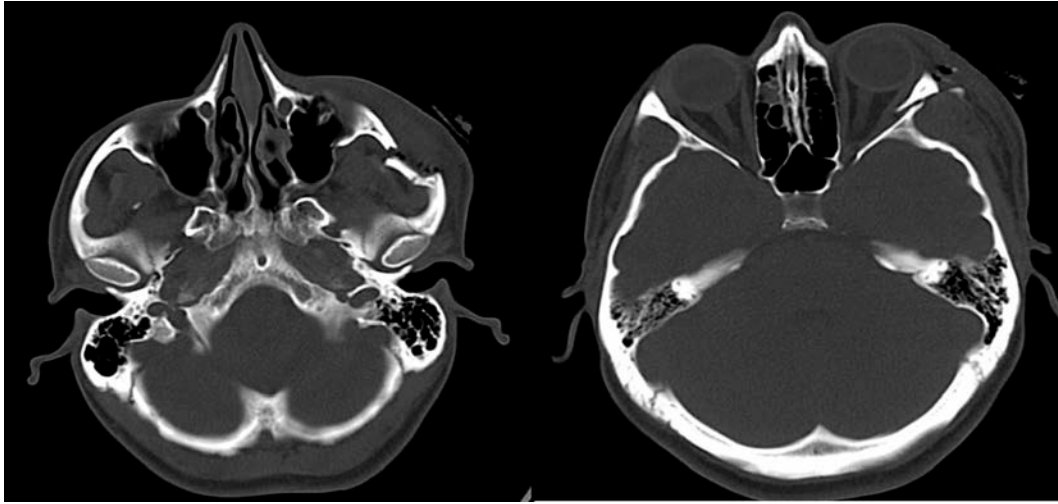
Preoperative axial computed tomography scans showing a displaced zygomatic complex
